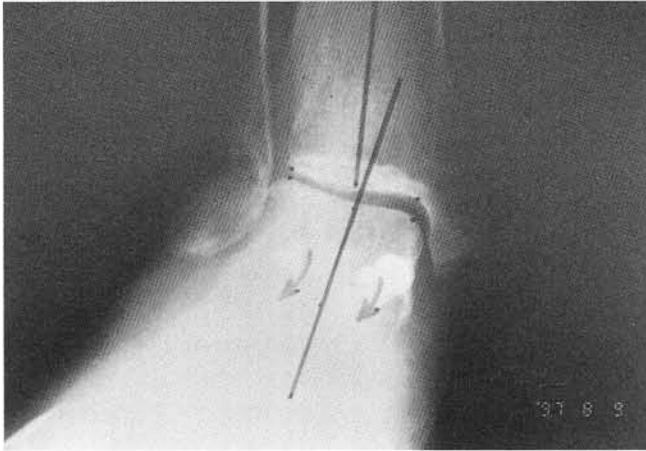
Anteroposterior ankle radiograph demonstrating early valgus stress following primary subtalar joint arthrodesis for an adult flatfoot syndrome.
